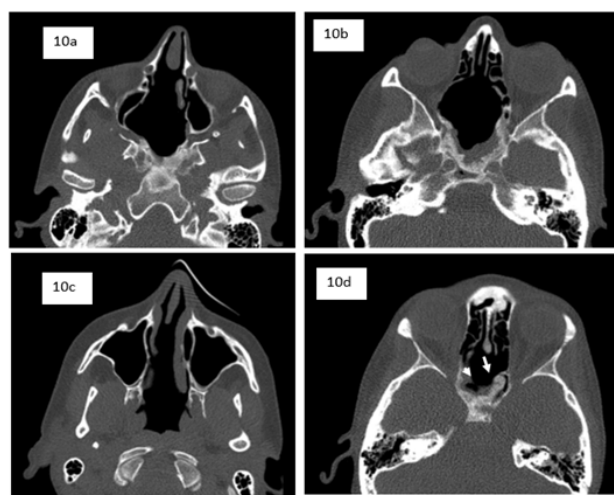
Bone window Sinus CT scan/Axial cuts/Persistence of small residual tumor close to the posterior wall of the sphenoid sinus and the left internal carotid artery.
